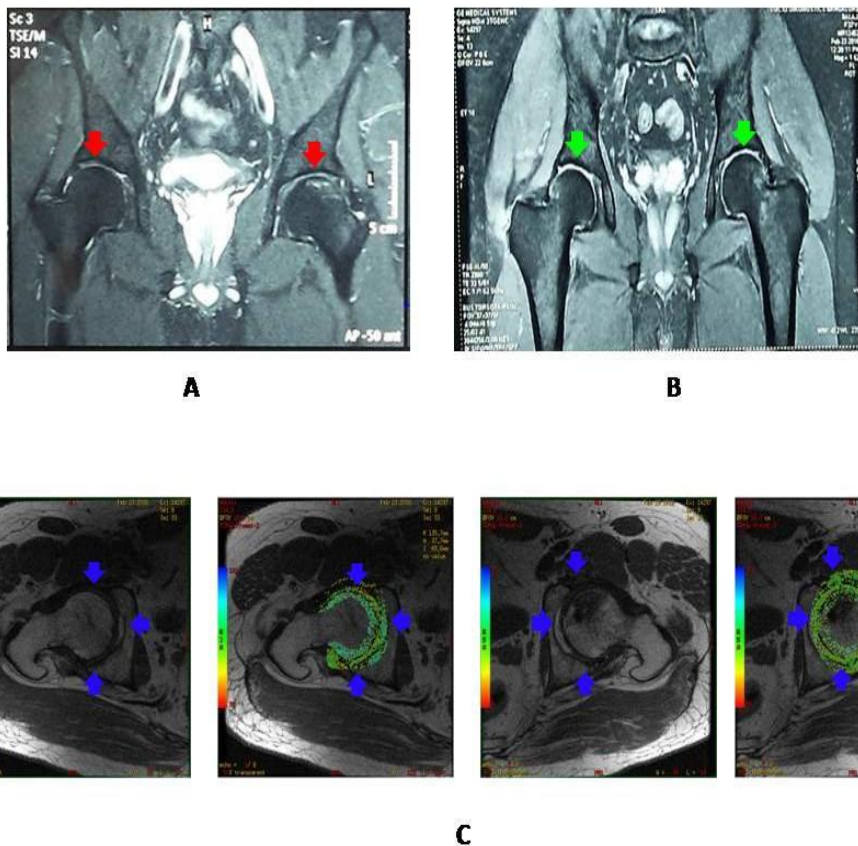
Case 3: MRIs pre- and post- therapy. A (Top Left) - Pre-therapy MRI; B (Top Right) - Post-therapy MRI; C (Bottom 4 images) - Post-therapy cartigrams consisting of alternating images of those with no colors for the lack depiction of hydration within the cartilage and those with colors of cartilage depiction of hydration. Red arrows indicate the location of loss of cartilage and green arrows show the location of the regeneration of cartilage, respectively, in the pre- and post-therapy MRIs; blue arrows show the cartilage location in the cartigrams.
